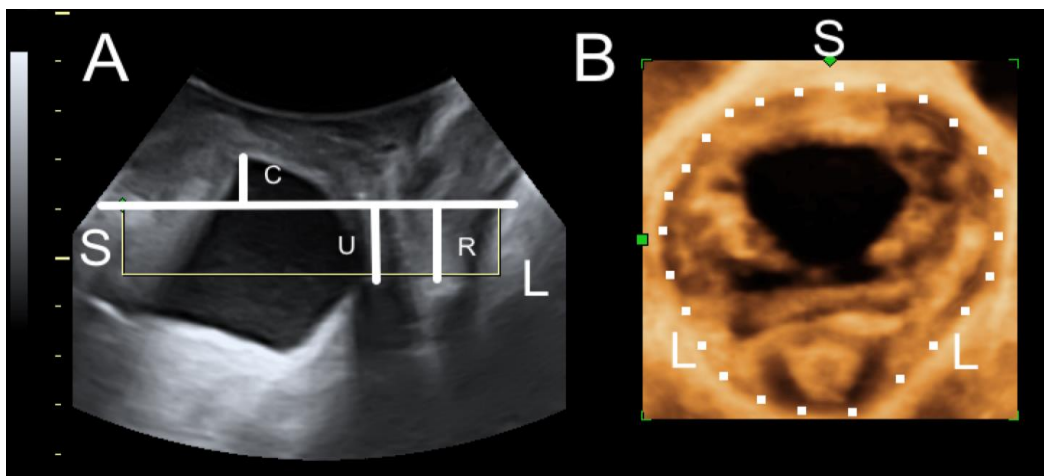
Quantification of organ mobility and hiatal distension on translabial ultrasound. (A) shows measurement of organ descent against the symphysis pubis (S), with C signifying bladder descent to about 1 cm below the symphysis, U showing uterine descent to about 1.5 cm above the SP, and R showing descent of the rectal ampulla to the same level. (B) demonstrates the measurement of hiatal area on Valsalva, with the dotted line indicating hiatal circumference. S= symphysis pubis, L= levator ani.
